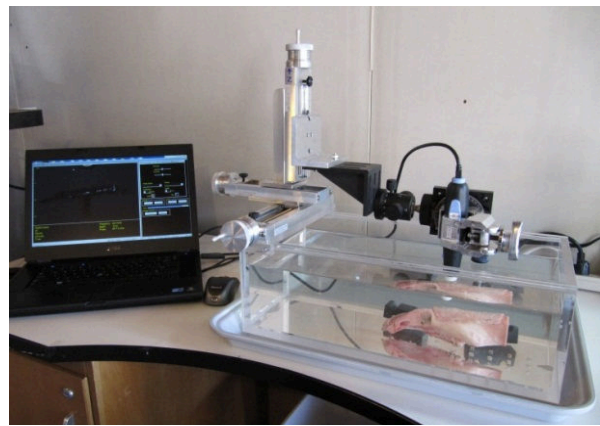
Acoustic test tank, with mechanical translation and rotation stages, clamp to hold ultrasound probe, and ultrasound image provided on laptop display.
